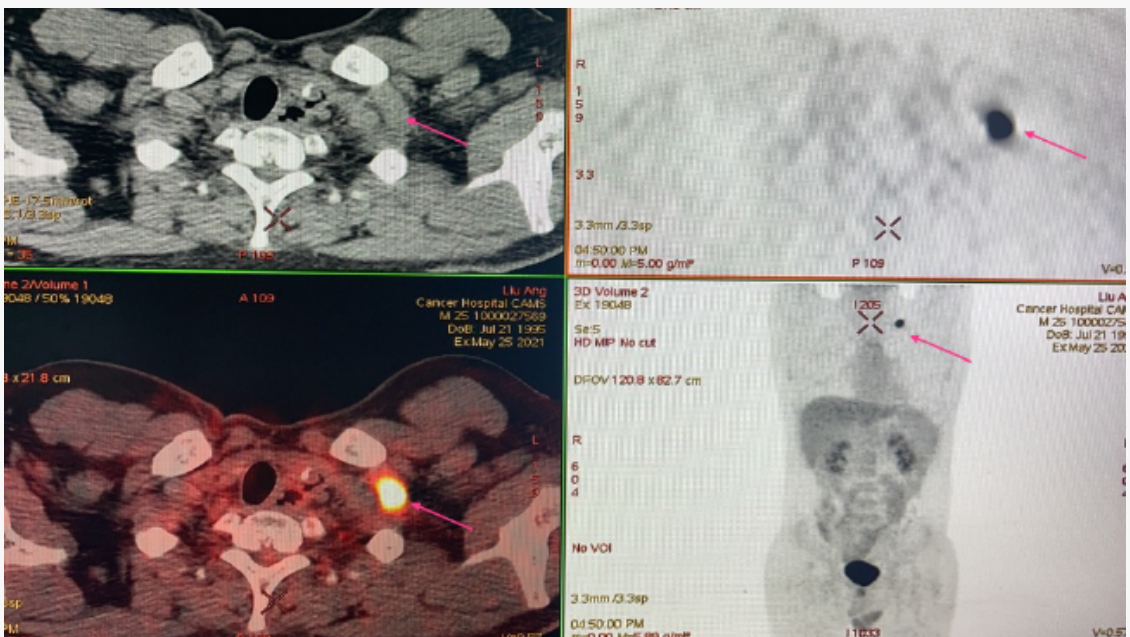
Postoperative supraclavicular LN recurrence by PET-CT during follow-up
